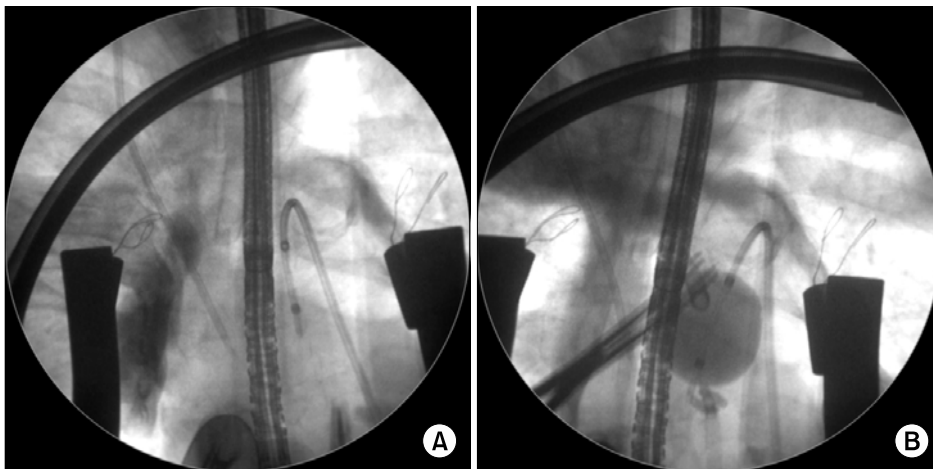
Intraoperative X-ray view of endoarterial balloon occlusion. (A) Catheter inserted through right femoral artery. (B) Balloon is positioned in the ascending aorta.
